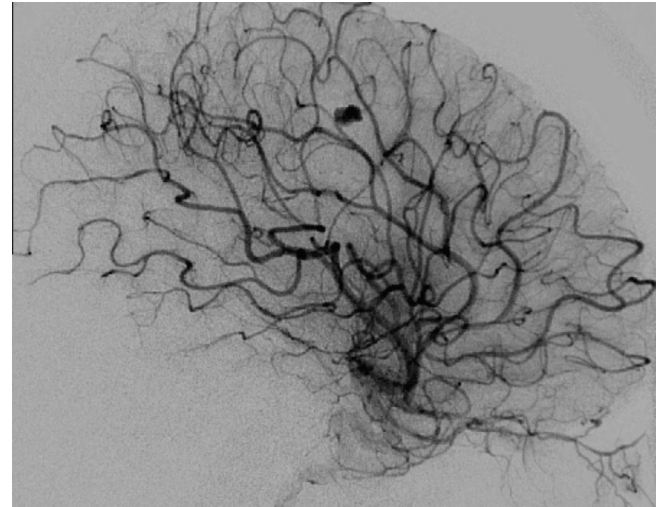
Catheter digital subtraction angiogram shows a left internal carotid artery injection which confirms the CT angiogram and MRI findings. A distal middle cerebral artery aneurysm is demonstrated without any associated arteriovenous malformation and no other aneurysms identified.
